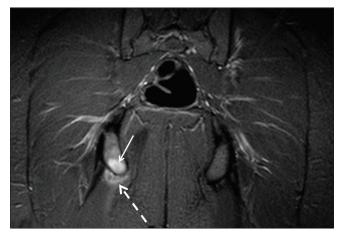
Coronal short tau inversion recovery magnetic resonance imaging image of a female patient demonstrating thickening and high T2 signal intensity edema/inflammation of the hamstring tendon and bursa, at its insertion on the right ischial tuberosity (dashed white arrow). Associated osteitis and bone marrow edema are noted in the right ischial tuberosity (white arrow). The patient presented with and was investigated for the left hip pain. These imaging findings should prompt the radiologist to suggest undiagnosed SpA. The patient was diagnosed with psoriatic arthropathy.
